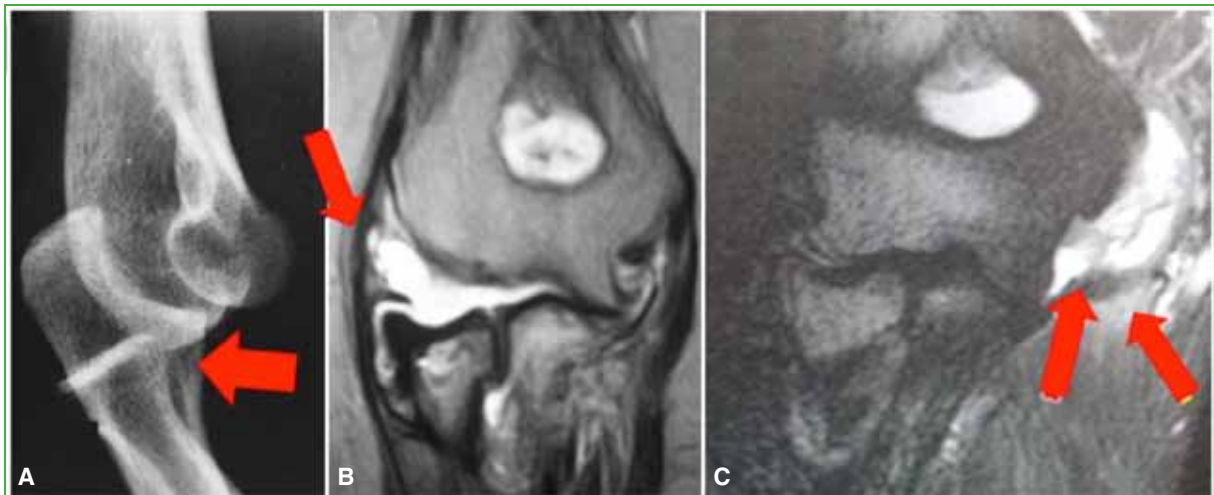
A. Lateral elbow radiograph showing the radial head positioned below the capitellum during a *pivot-shift* maneuver in PLRI. B. Coronal elbow MRI. Avulsion of the lateral ligament complex. C. Coronal MRI of the left elbow. Avulsion of the medial ligament complex.
